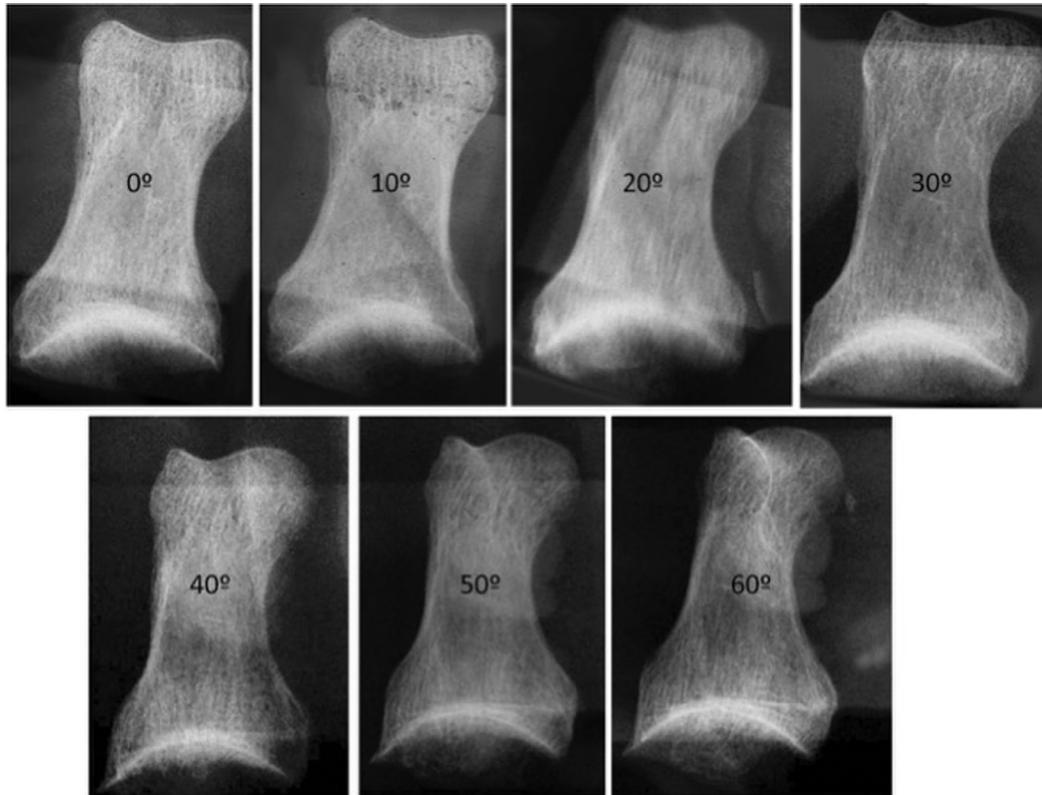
Radiographs of 0° to 60° phalanx rotation.
